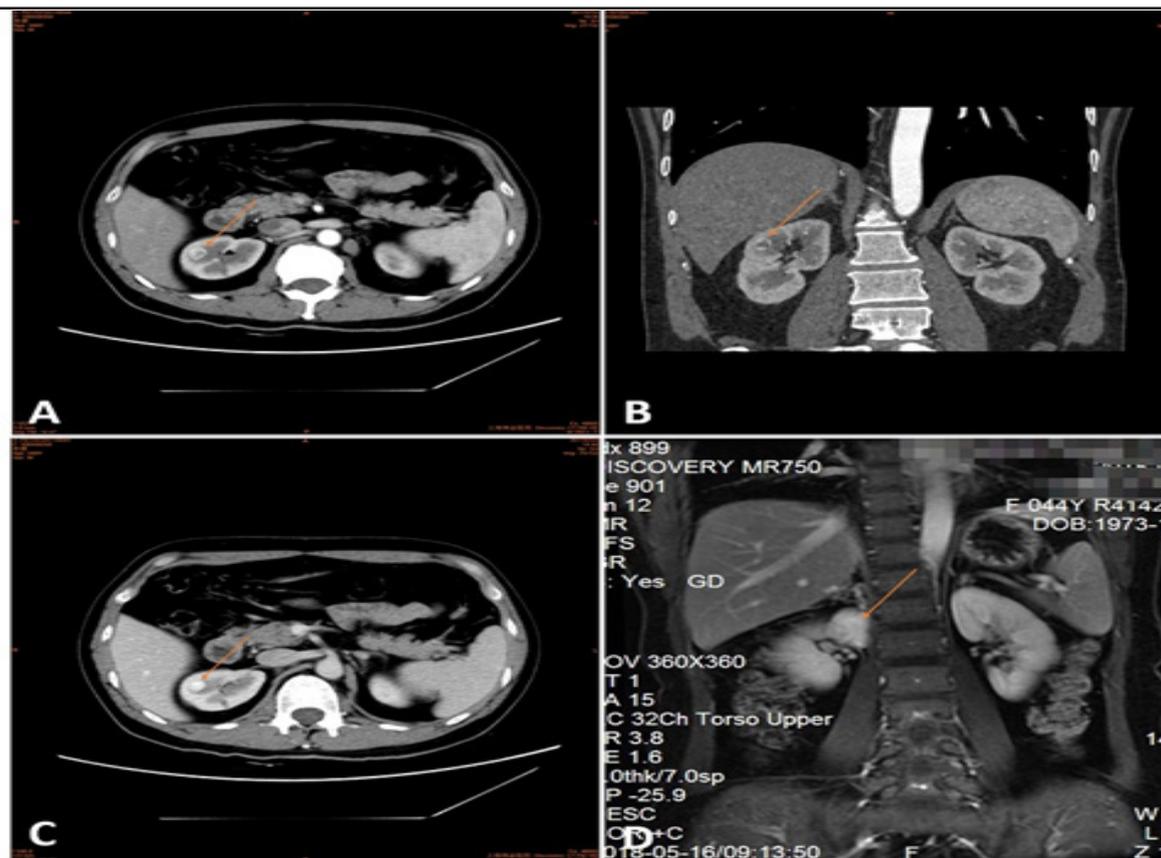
Represented imaging features of AH. A contrast-enhanced CT scan showed a well-circumscribed solid tumor in the right kidney with peripheral enhancement at the arterial phase (A, axial; B, coronal), and homogeneous enhancement at portal phase (C). Coronal enhanced CT demonstrated a homogeneous enhanced lesion arising on the adrenal gland at arterial phase (D).
